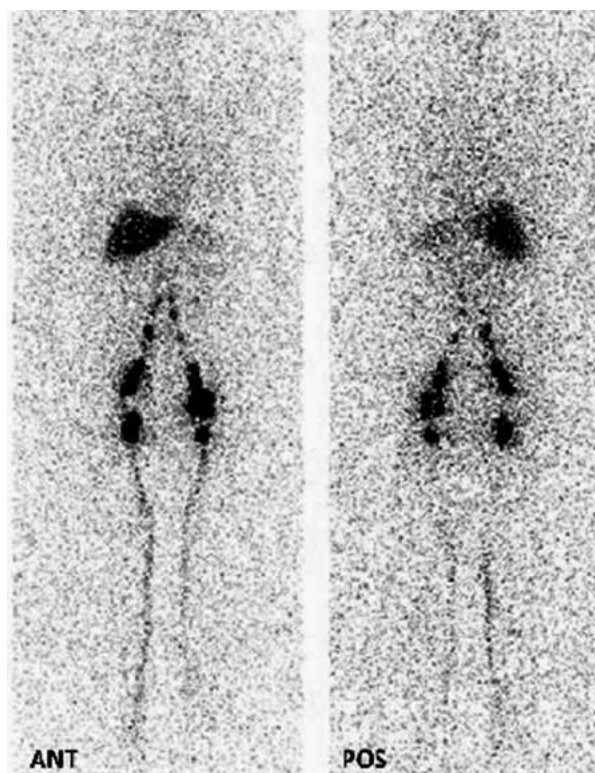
Normal lymphoscintigraphic finding 4h after administration of radiotracer [17]
